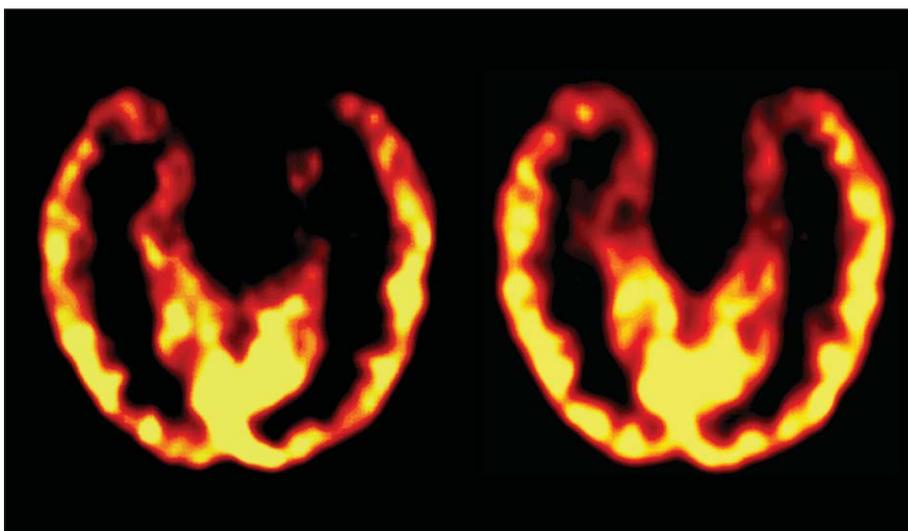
[ $^{11}\text{C}$ ]flumazenil-PET (FMZ-PET) in a patient with right TLE and mesial temporal sclerosis on MRI, showing a typical decreased FMZ binding over the atrophic hippocampal region.
